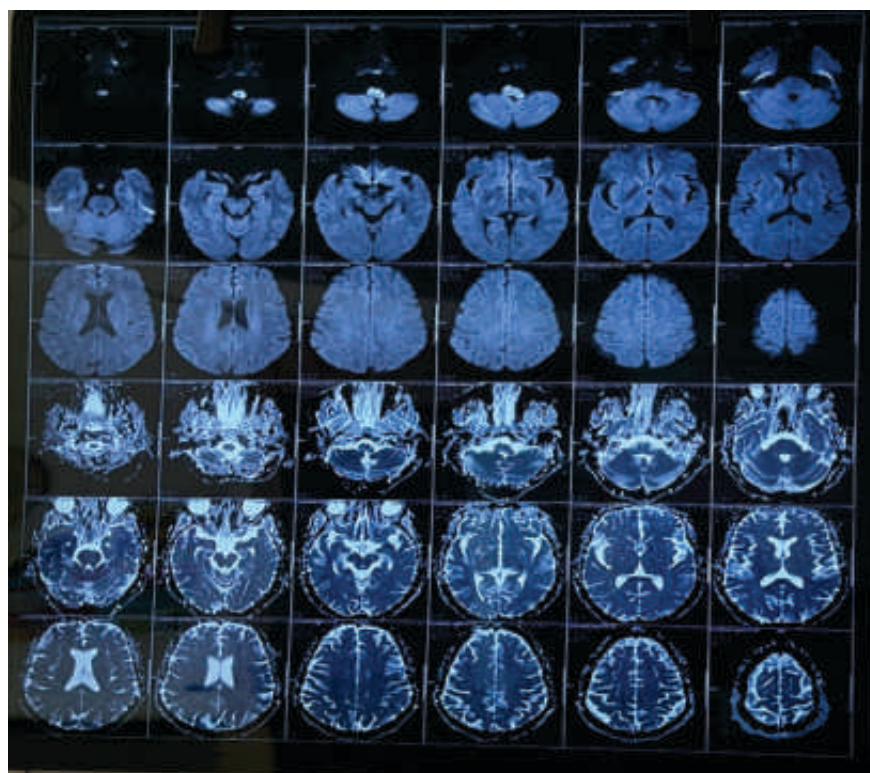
MRI Brain showing demyelination appearing hyperintense on T2 & FLAIR and hypointense on T1 with patchy areas of diffusion involving more than 3/4th of medulla
